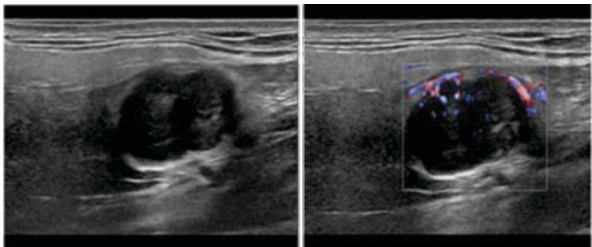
USG picture of the right parotid swelling, a-with Doppler b-without Doppler
